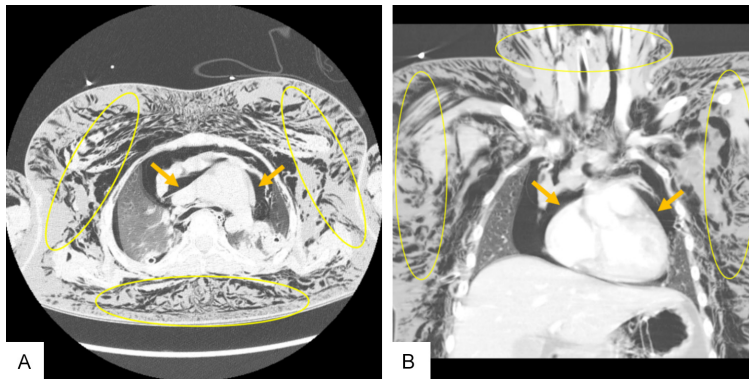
Chest computed tomography images showing extensive subcutaneous emphysema, pneumomediastinum, and craniocaudal air dissemination. A. Axial view. B. Coronal views. White ovals mark areas of subcutaneous emphysema; yellow arrows indicate pneumomediastinum.
